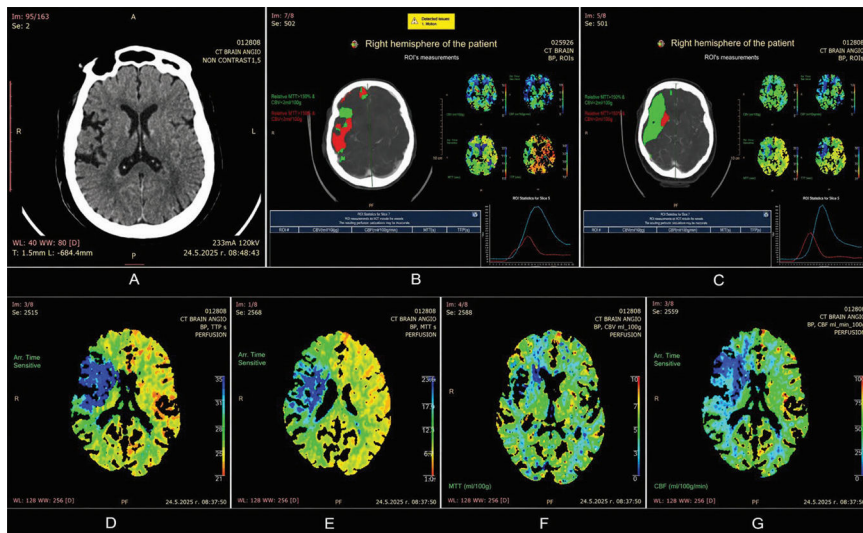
Brain CT and perfusion imaging. Non-contrast CT without clear early ischemic changes (A). Perfusion maps (B-G) MTT, TTP, CBV and CBF demonstrating prolonged transit time and reduced cerebral blood flow with relatively preserved blood volume in the right hemisphere, consistent with perfusion mismatch and ischemic penumbra and infarct core
